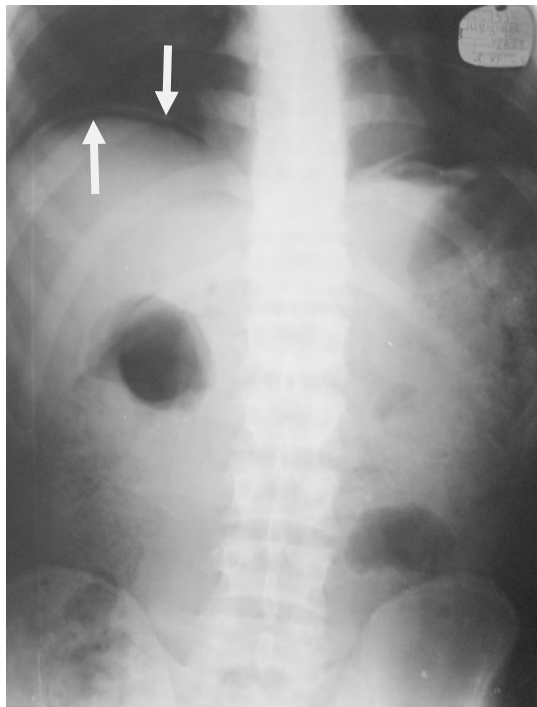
Abdominal plain film. Frontal view. Gas accumulation in abdominal cavity (pneumoperitoneum – chest and abdominal films visualizes air below the diaphragm).
